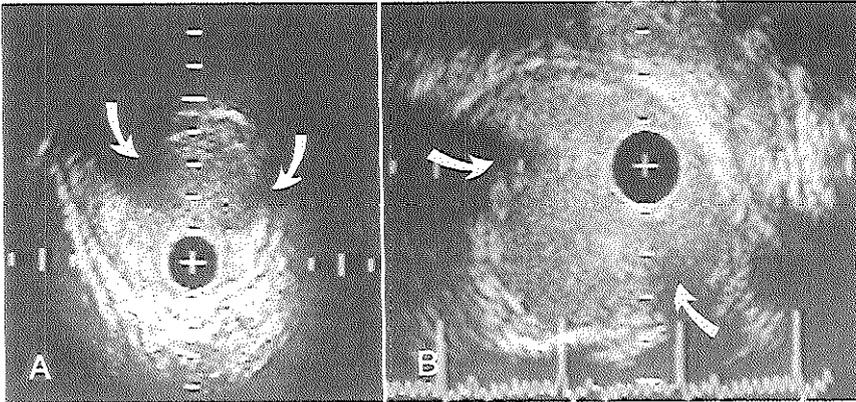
A, Intravascular ultrasonographic image of a superficial femoral artery after balloon dilatation. The catheter is positioned in a crescent-shaped lumen, which is included between the vessel wall and a large intimal flap. Note that the false lumen and the opposite wall behind the dissection are visualized only in the area of perpendicular orientation to the ultrasound beam. A dropout of the underlying structures is observed in the presence of a narrow angle of incidence of the ultrasound beam on the dissection plane (arrows). B, Intravascular ultrasonographic image of a superficial femoral artery after balloon dilatation. Large dropouts of the two extremities of the dissected plane (curved arrows) and of the underlying vessel wall and lumen cause interpretation problems. Note that the omnidirectional backscatter of blood clearly delineates the half-moon shape of the true lumen.
